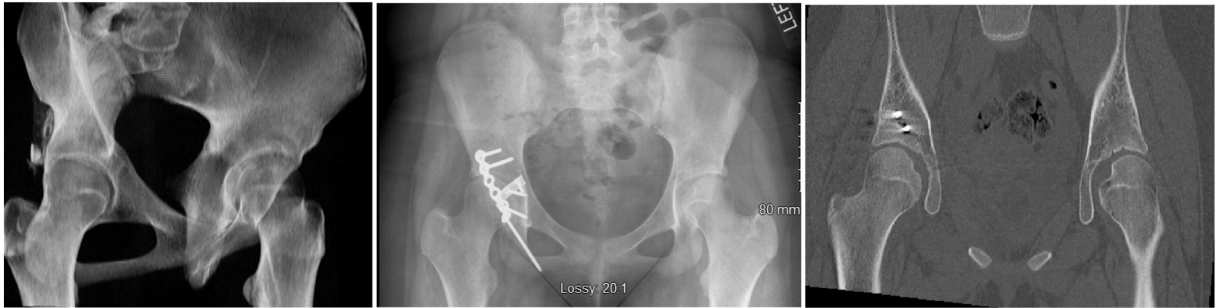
A–C. A). 3D Recon image of a right posterior wall acetabulum fracture. B). Immediate postoperative radiographs and C) immediate postoperative CT scan showing interval hardware placement and no preexisting CAM lesion.
